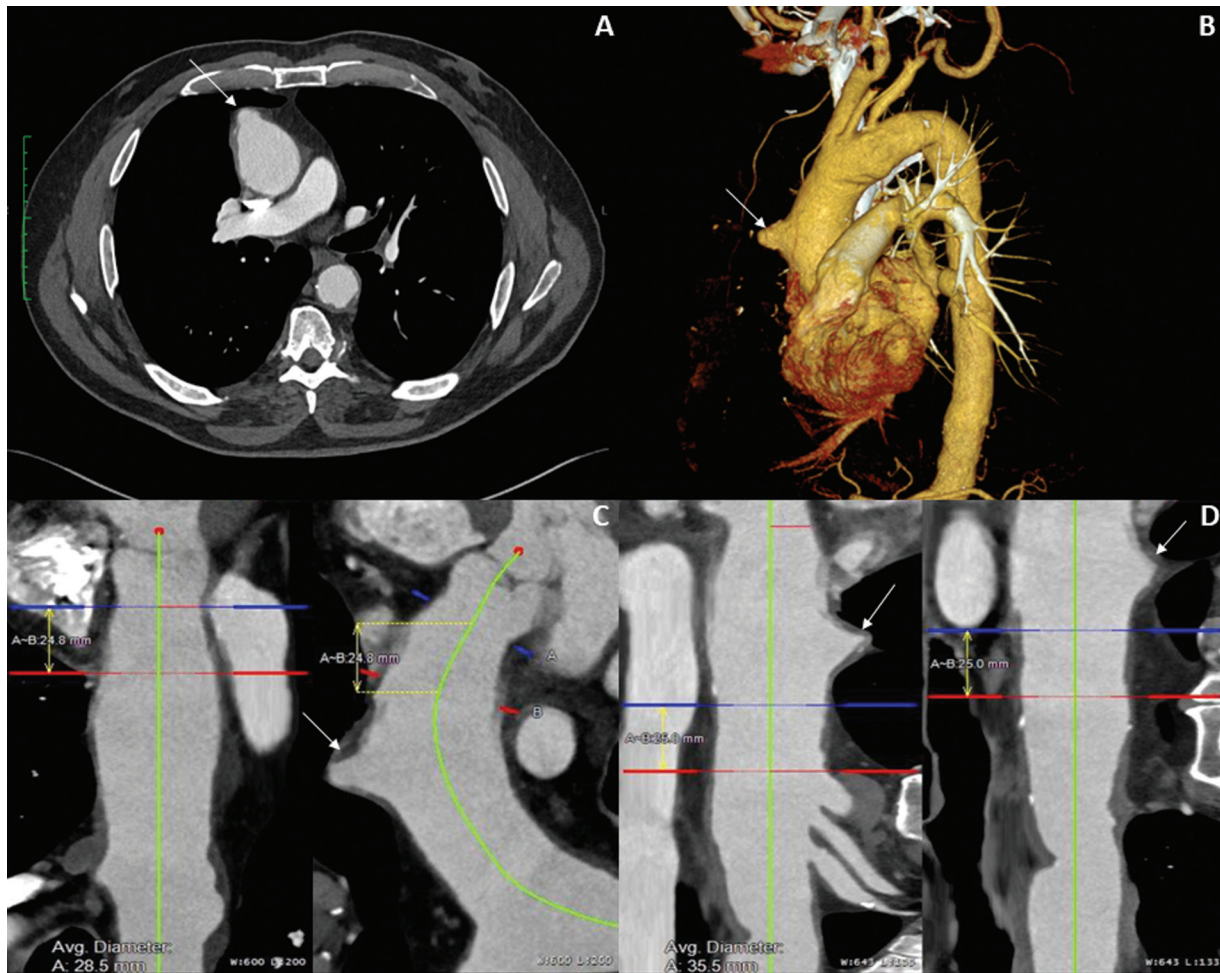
Preoperative axial (A) and 3D-reconstruction (B) Computed tomography angiography images demonstrating ascending aortic penetrating ulcer (arrows). Curved planar reformats with corresponding measurements of average proximal (C) and distal (D) landing zone diameters are also shown.
